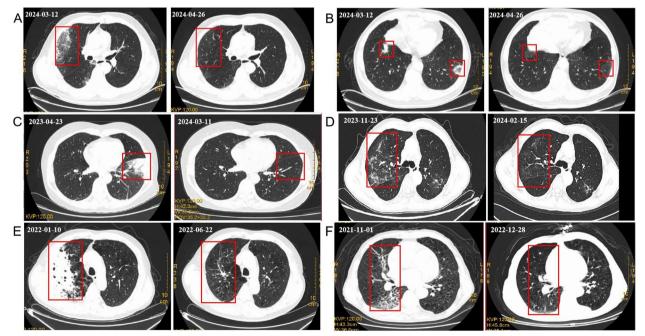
Chest CT scan before and after treatment (Figures A and B show chest CT scans of the same patient. The left figures are before treatment and the right figures are after treatment. The rectangles indicate the focus.)
